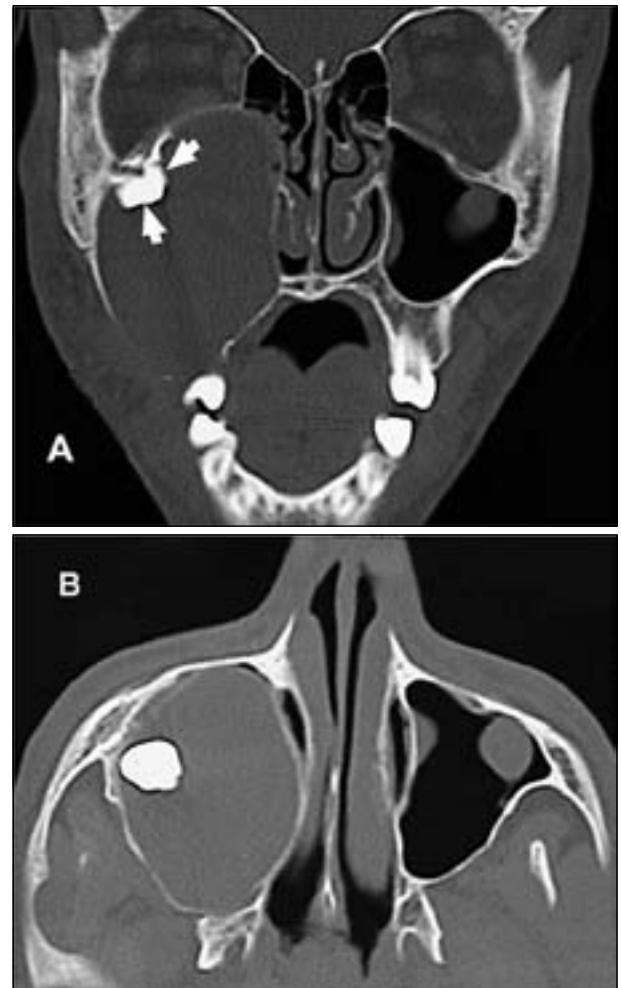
Coronal (A) and axial (B) computed tomography scans showing a mass in the region of the right maxillary sinus that caused superior displacement of the tooth
